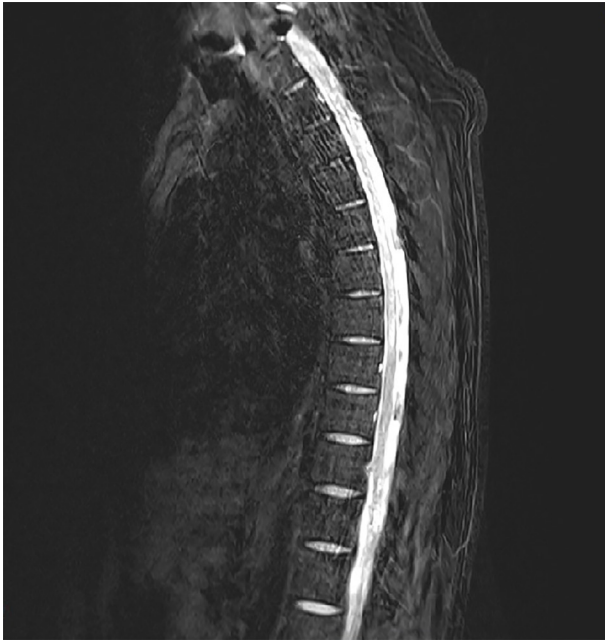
Spine magnetic resonance imaging made on admission. High signal intensity was apparent within the left spinal cord at level T2-8 on a T2-weighted image.
